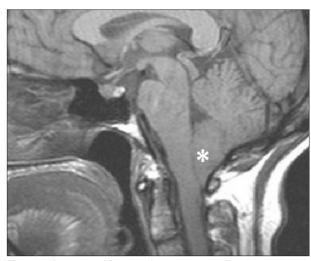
A MR imaging of Chiari malformation type-I. *Tonsillar herniation.
